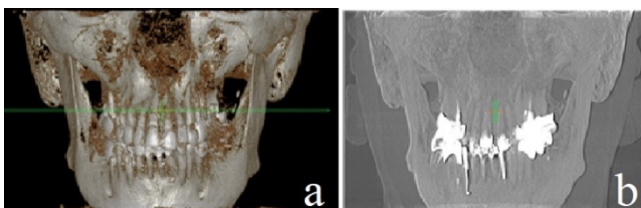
The use of CBCT in orthodontics: a - VR mode (volume rendering mode) in the projection of the 3D visualization window; b - MIP mode (maximum intensity projection) of the 3D visualization.
